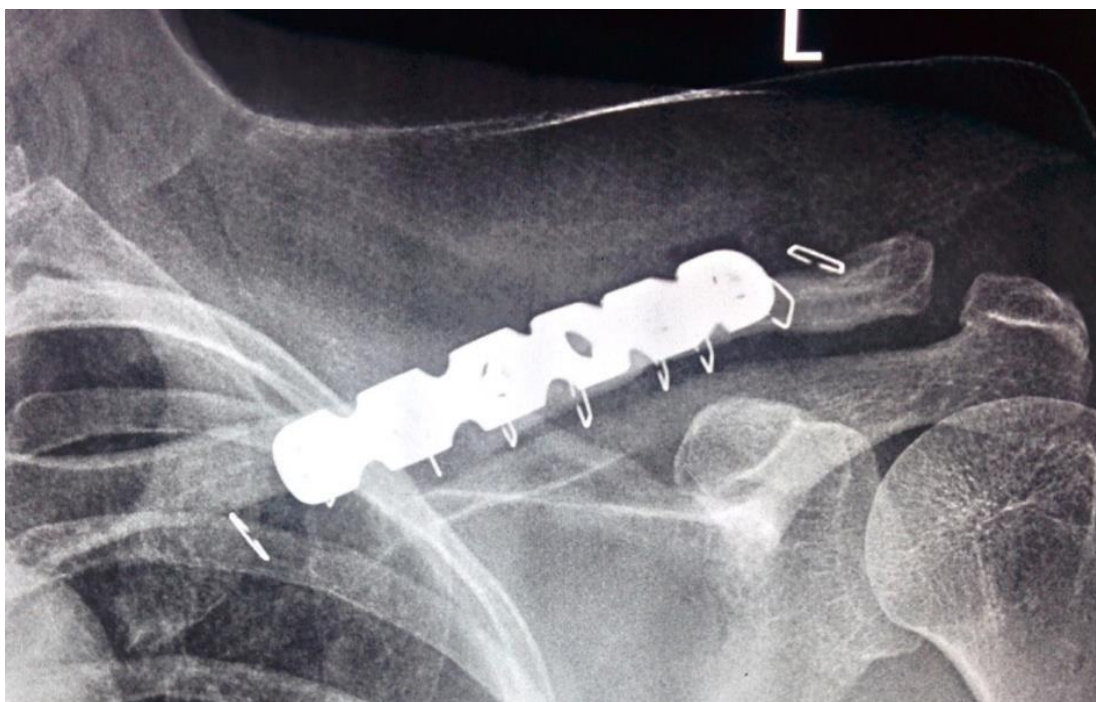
Immediate post operative radiograph showing fracture reduced with a 6 holed RECON plate and screws
